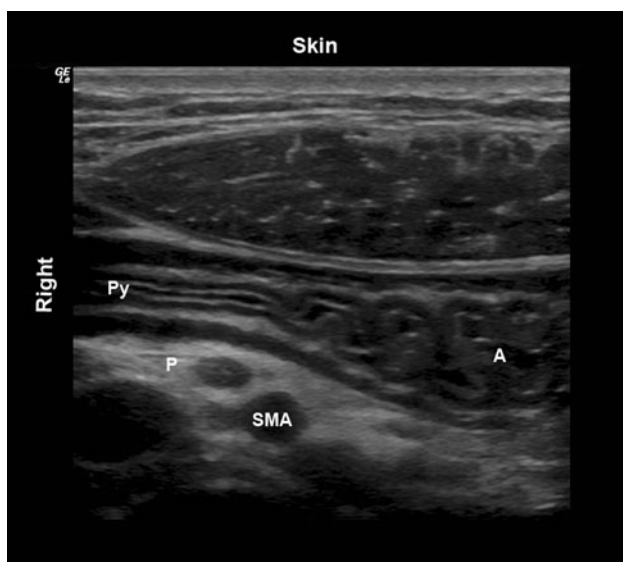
Axial sonogram of the empty antrum using a linear high-frequency transducer, allowing identification of five gastric wall layers. A = antrum; Py = pylorus; P = pancreas; SMA = superior mesenteric artery
